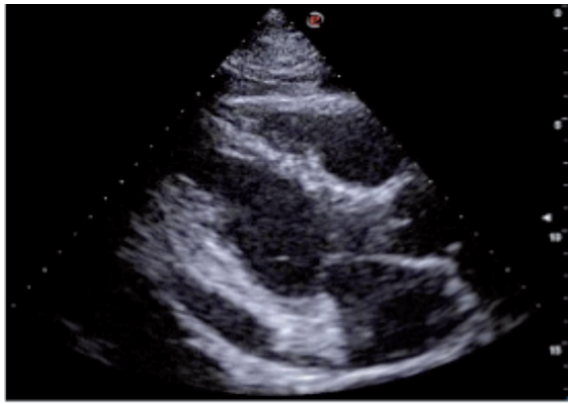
Parasternal long axis echocardiographic view showing pericardial effusion, predominantly localized along the inferolateral left ventricular wall and extending to the region surrounding the right ventricle.
